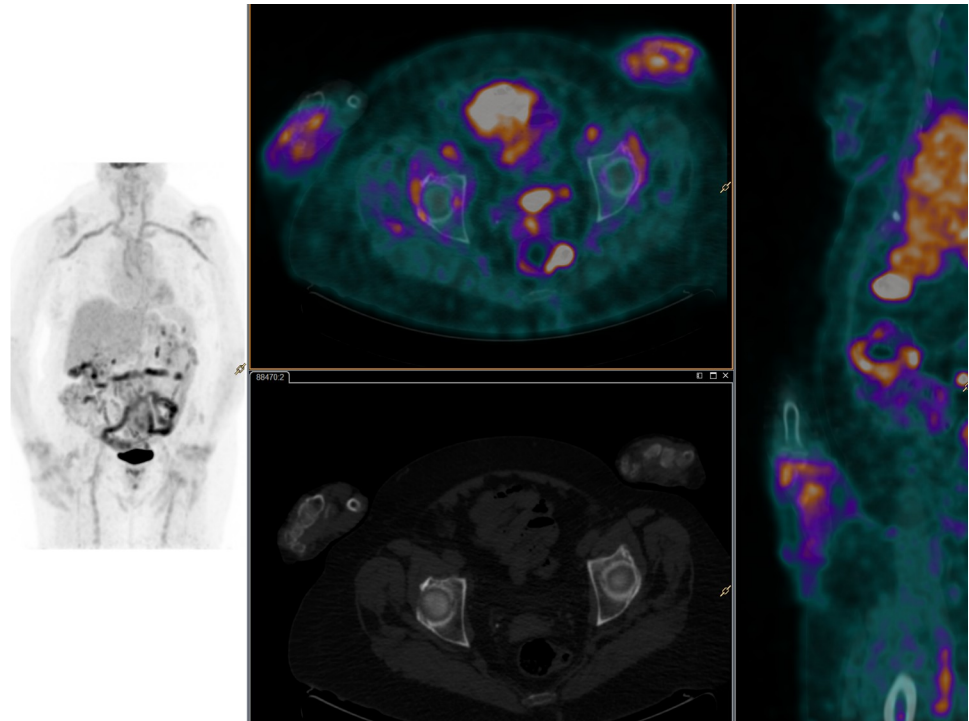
^{18}F -FDG-PET/CT images. A 78-year-old woman with diagnostic of elderly onset rheumatoid arthritis [EORA]. Fused ^{18}F -FDG PET/CT and MIP images showed increased metabolism in aortic wall and supraortic vessels which corresponded to vasculitis. Increased ^{18}F -FDG uptake in peripheral joints was also described with shoulder involvement. Inflammatory activity in the wrists was also observed, as a characteristic arthritis in this pathology.
